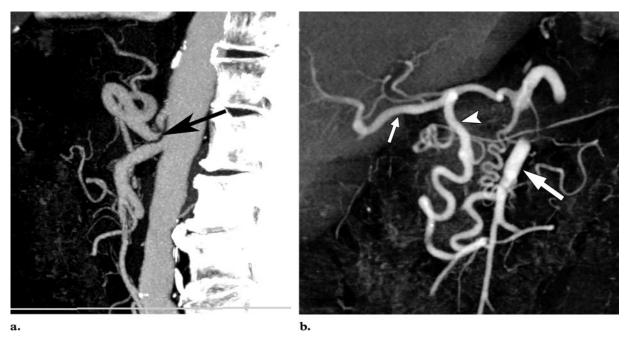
(a) Sagittal 3D image of a patient with epigastric pain demonstrates acute angulation and narrowing of the proximal celiac axis. There is minimal poststenotic dilatation, which creates a "hooked" appearance (arrow) that is characteristic of median arcuate ligament syndrome. (b) Coronal oblique CT angiogram of the same patient reveals a prominent collateral vessel and dilatation of the gastroduodenal artery (arrowhead) that is supplying the common hepatic artery (short arrow) off the superior mesenteric artery (long arrow). This configuration is a common collateral pathway seen in patients with celiac axis stenosis. The patient underwent surgical decompression and experienced relief of symptoms.
